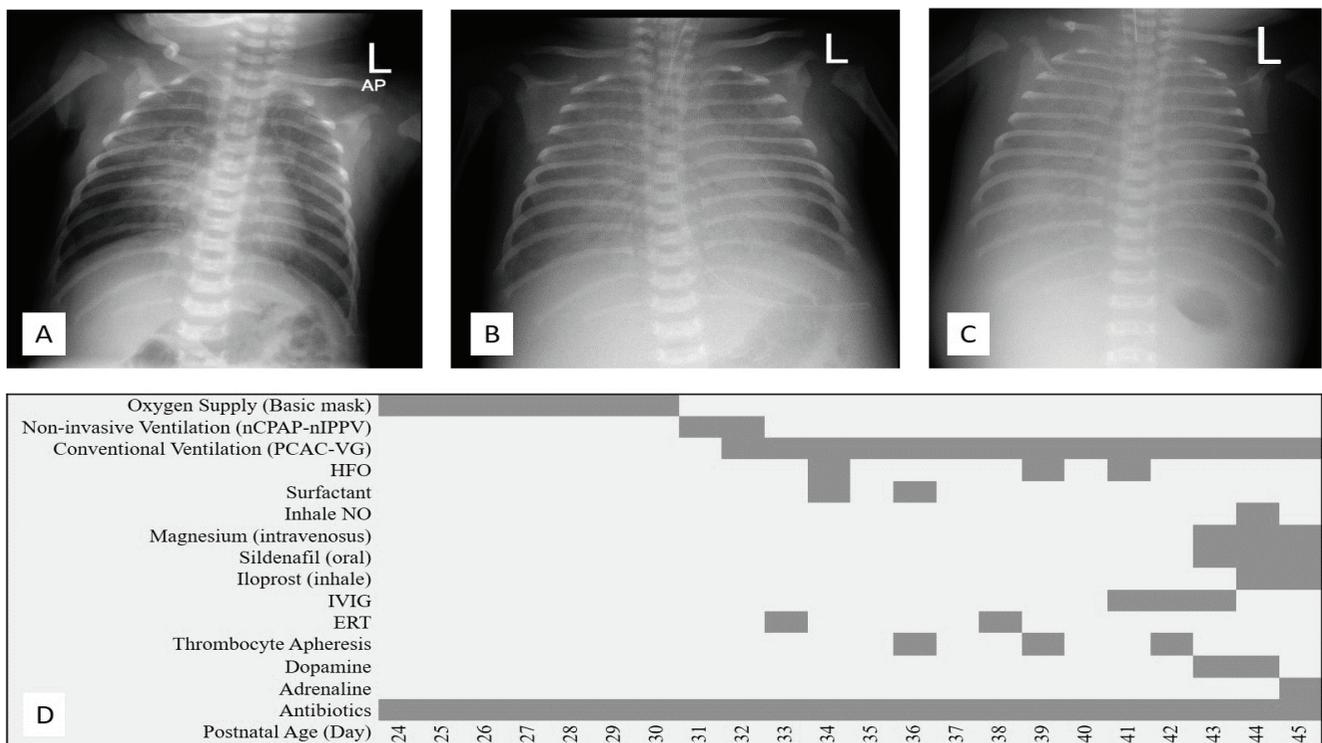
A: Initial chest X-ray of Case 1 (stars: cupping of costochondral junctions); B: Chest X-ray of case 1 at the time of NARDS diagnosis; C: Chest X-ray of case 1 on follow-up (arrow: squaring of the inferior scapular angle) D: Treatment regimen of case 1
